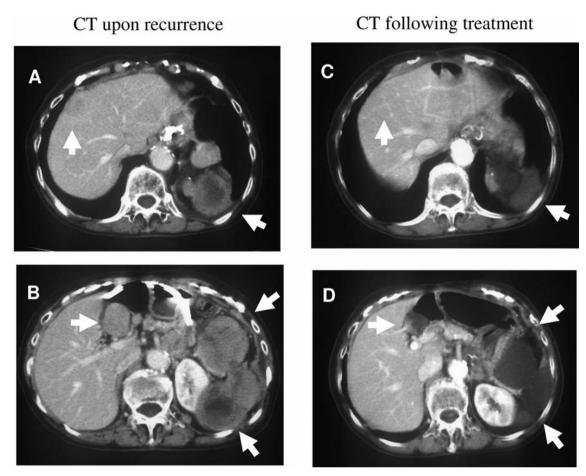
CT upon recurrence: A, Discrete tumors were found in the anterior superior segment of the liver and the left upper quadrant. B, A discrete tumor was found in the hepatic portal region and lobulated tumors were found around the intestinal tract in the left lower quadrant. CT following treatment: C, The tumors in the anterior superior segment of the liver and the left upper quadrant shrank; D, the tumor in the hepatic portal region and the lobulated tumors in the left lower quadrant exhibited cyst-like changes.
